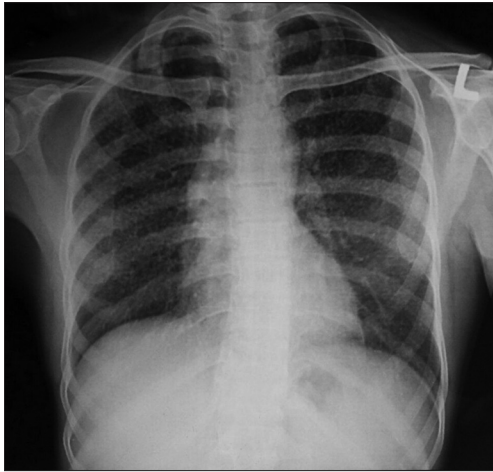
Chest X-ray showed miliary mottling suggestive of miliary tuberculosis
